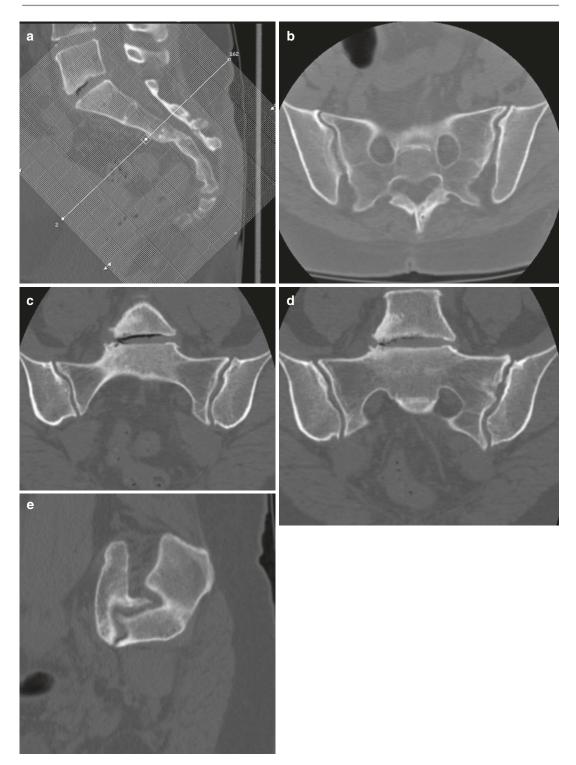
CT of the sacrum and sacroiliac joints, (a) localiser image of the sacrum, the scan planes are acquired from this image, the axial line transversing the image is in the true axial plane sacrum. Figs. (b–d) are true coronal through the sacroiliac joints and (e) is a sagittal reconstruction (usually not required for sacroiliac disease but may be beneficial for other pathology including fracture assessment)
